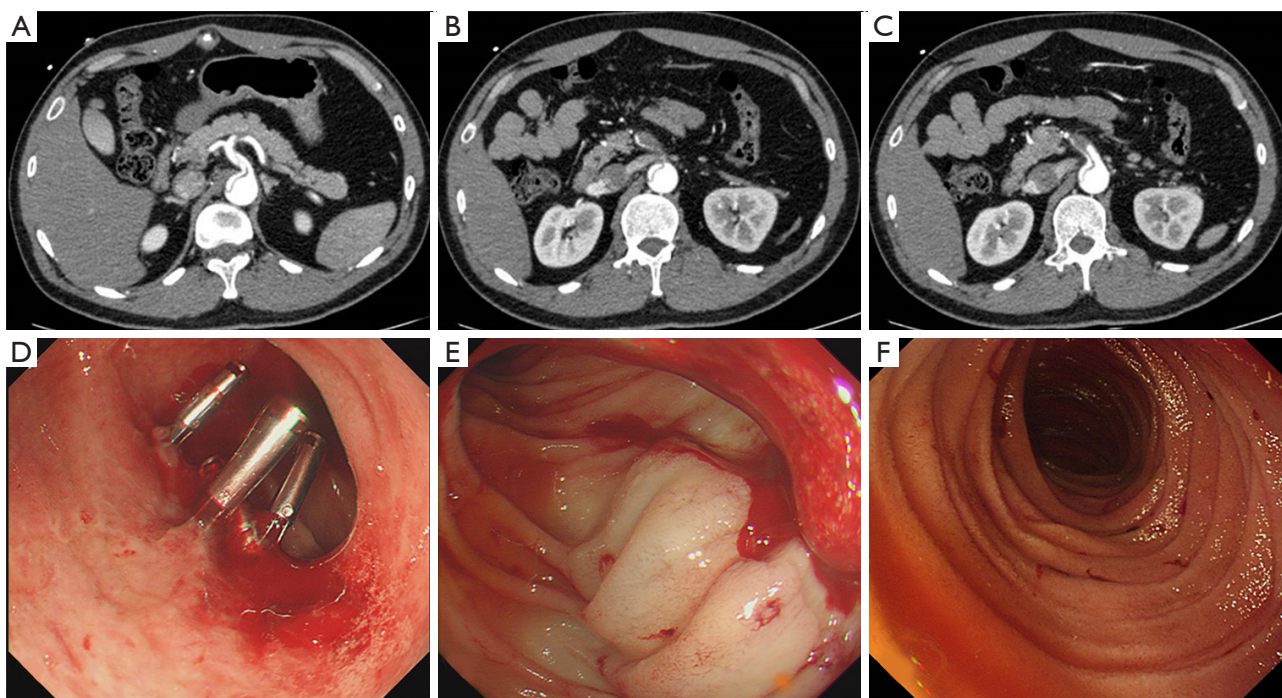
Demonstration of aortic CTA and emergency gastroscopy in a patient with severe gastrointestinal bleeding. The patient, a 33-year-old man, exhibited abnormal blood supply to the celiac trunk (A) and superior mesenteric artery (B,C) on preoperative aortic CTA. Upper gastrointestinal bleeding with multiple ulcers in the bulb (D) and descending (E,F) segments occurred, and recurrent bleeding was observed 1 day after total aortic arch replacement. CTA, computed tomography angiography.
